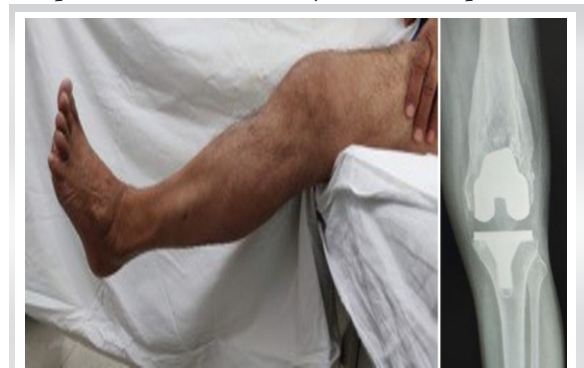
Two-year follow-up X-ray (AP view).
